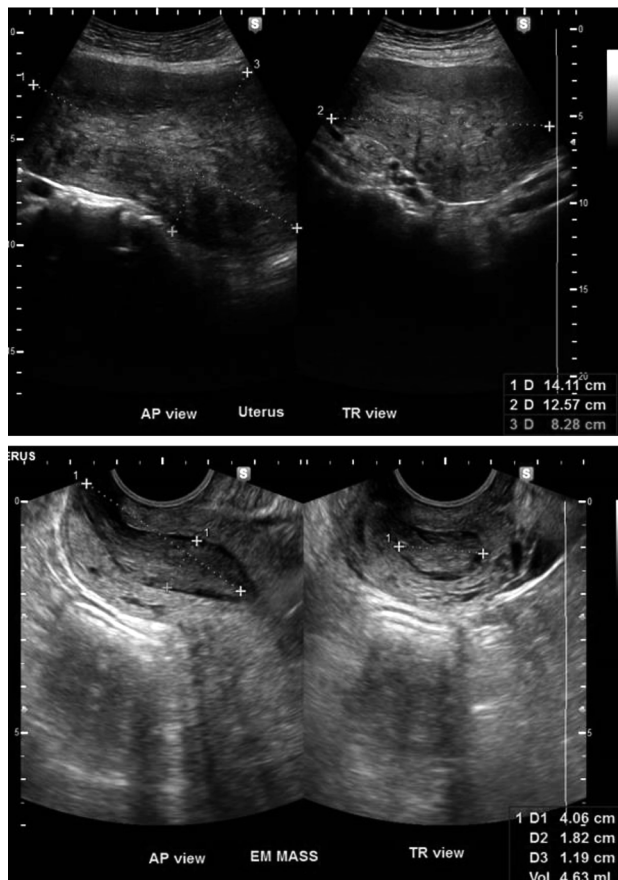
Transvaginal ultrasound A. Anteroposterior (AP) and transverse (TR) views of the uterus. B. Anteroposterior (AP) and transverse (TR) views of endometrial mass
